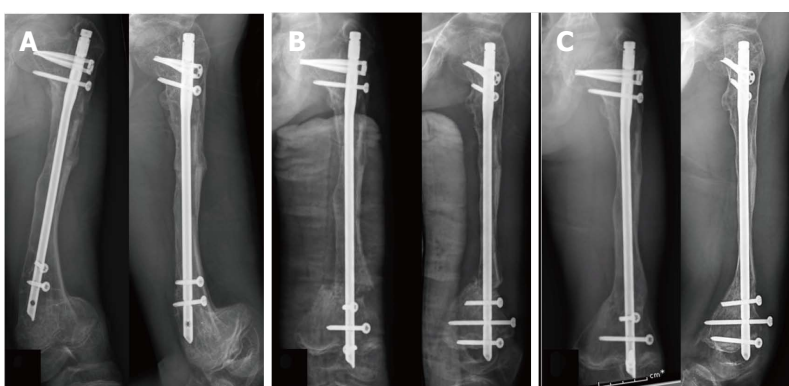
Clinical presentation of case 3 during the second operation. A 16-year-old male with type III osteogenesis imperfecta presented with progressive deformity of left distal femur after first humeral nail fixation for 10 mo. Plain radiographs in anteroposterior and lateral views on preoperative period (A), immediately after corrective osteotomy with humeral nail fixation (B), and 9 mo after humeral nail fixation (C).
